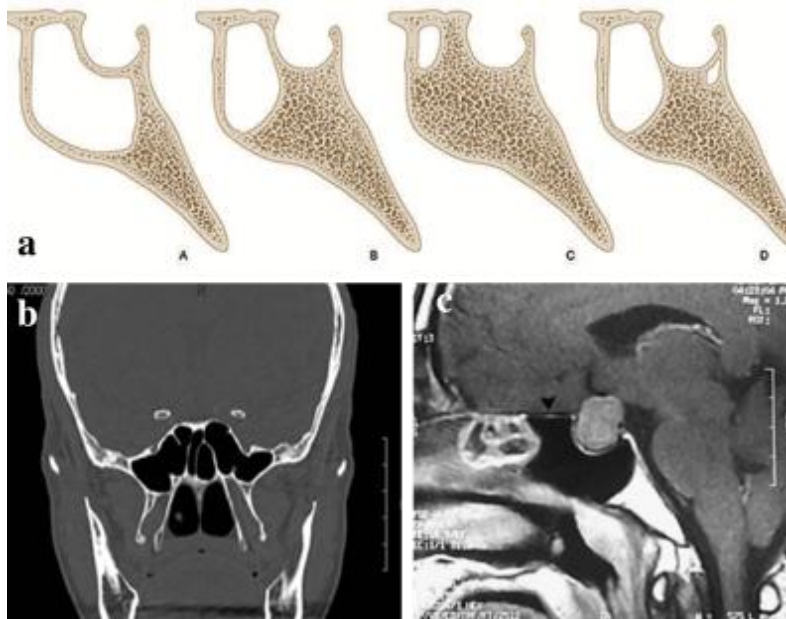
(a) Four types of sphenoid sinus pneumatization: A) sellar, B) presellar, C) conchal, D) postsellar. (b) Computed tomography image of a well-pneumatized sphenoid sinus with multiple vertical and horizontal septations. (c) magnetic resonance imaging of the sella, showing a postsellar pneumatization of the sphenoid sinus and a pneumatization of the planum sphenoidale (arrow)³⁷.
